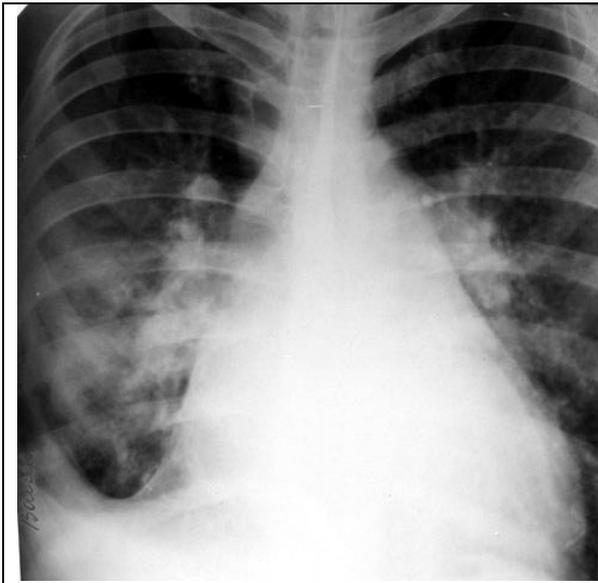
The frontal chest radiograph. Pericardial effusion: a smoothness of contours of heart, its triangular form. Pleural effusion: In the bottom department of the right pulmonary field shadow is defined. Shadows of hilums are increased, because of expansion of vascular trunks forming them.
